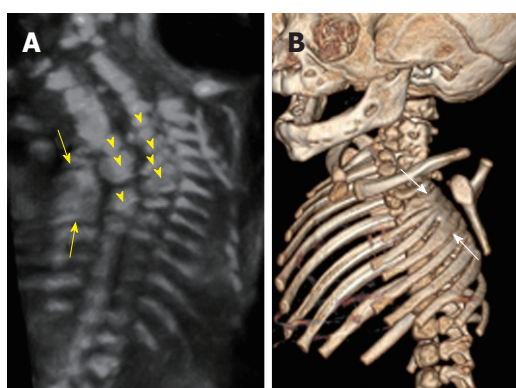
Rib fusions. Grayscale 3D ultrasound image (A) of a 21 wk fetus demonstrate fusion of multiple left sided ribs (arrows) as well as multiple segmentation anomalies (arrowheads) resulting in congenital cervicothoracic kyphoscoliosis. Postnatal multidetector unenhanced computed tomography (B) of the thorax with volume rendering demonstrates bony fusion of multiple left sided ribs (arrows) as well as multiple segmentation anomalies and cervicothoracic dextroscoliosis.
